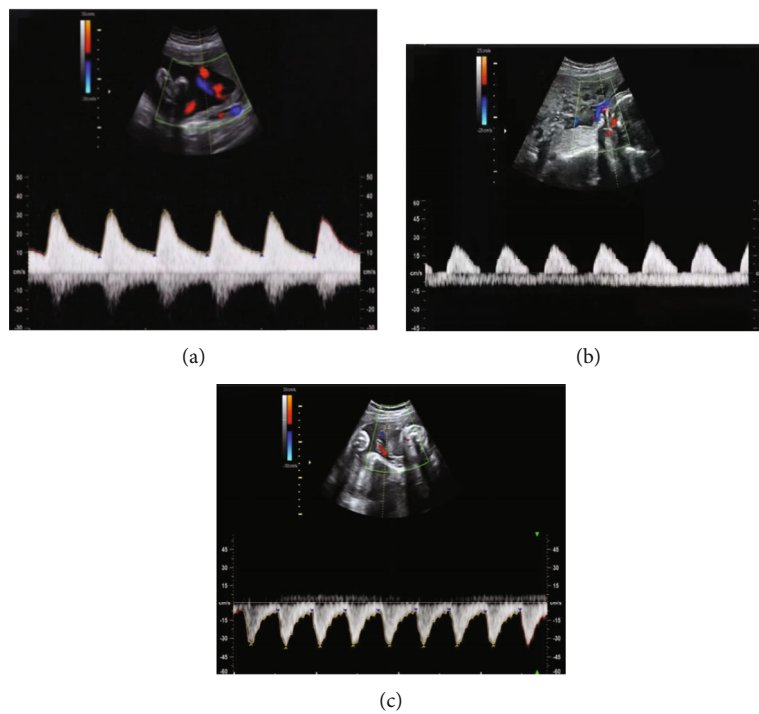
Blood flow spectra of fetal UA measured by transabdominal ultrasound. (a) Doppler waveform of UA blood flow in the normal group. (b) Doppler waveform of abnormal UA blood flow in the mild group. Diastolic blood flow signal of UA disappeared. (c) Doppler waveform of abnormal UA blood flow in the severe group. The UA diastolic blood flow signal was reversed.
